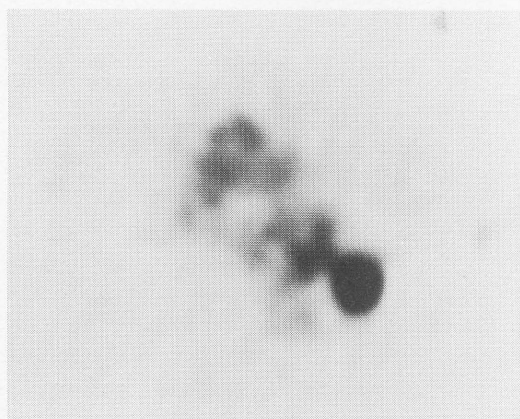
77-year-old-female. Adenocarcinoma, stage IIIB, T2N3M0 (case 10). CT before therapy (A) showed a mass density in the left lung field, and high FDG uptake was noted in this lesion and mediastinal lymph node metastases (B). After radiation therapy of 60 Gy, the tumor decreased in size on CT (C), and FDG uptake also decreased (D).
